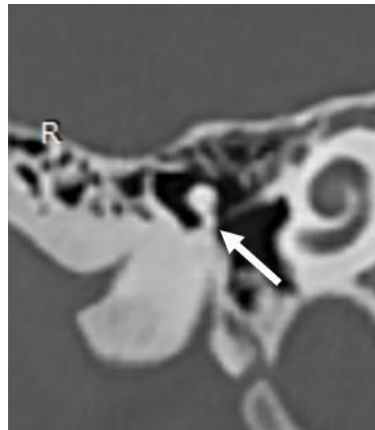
Axial (a) and coronal (b) sections of HRCT temporal bone showing right external auditory canal atresia (arrows)
